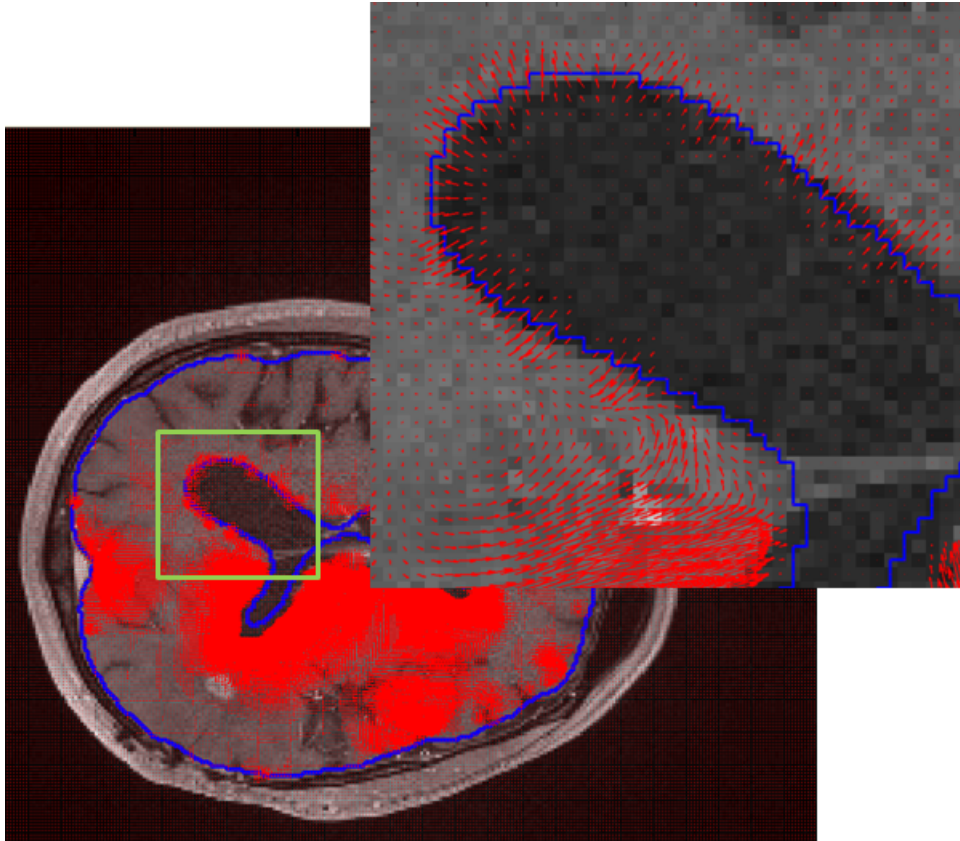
Displacement field (in red) overlaid on a sample MRI slice of the reference volume, with the boundary of the target volume indicated with the blue contour. A closer look to the ventricle of the hemisphere without tumor.
